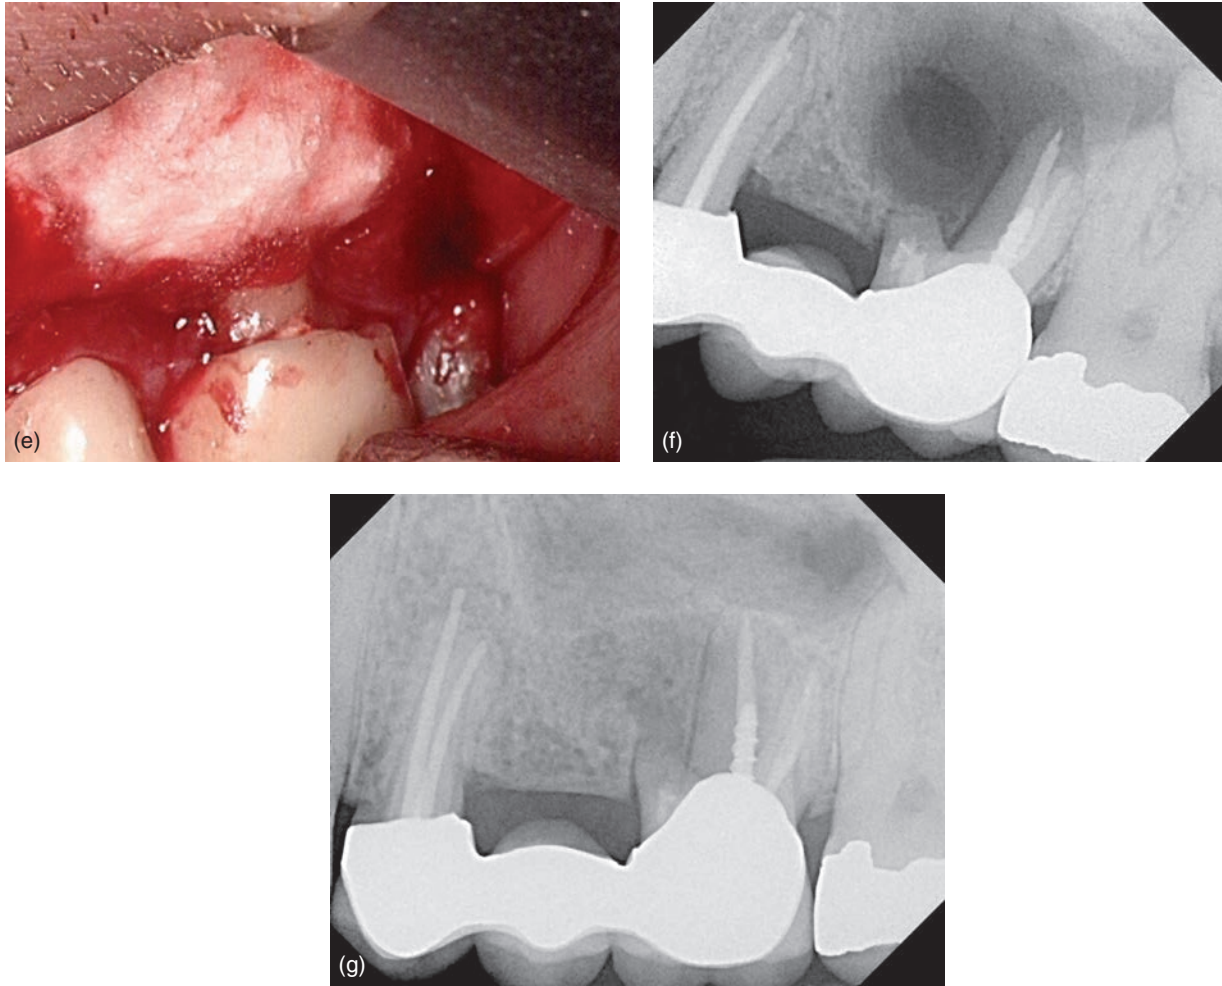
(Continued) (e) Collacote resorbable collagen membrane; (f) postop radiograph; (g) 8 month follow-up showing bone fill plus reformation of the sinus membrane.
